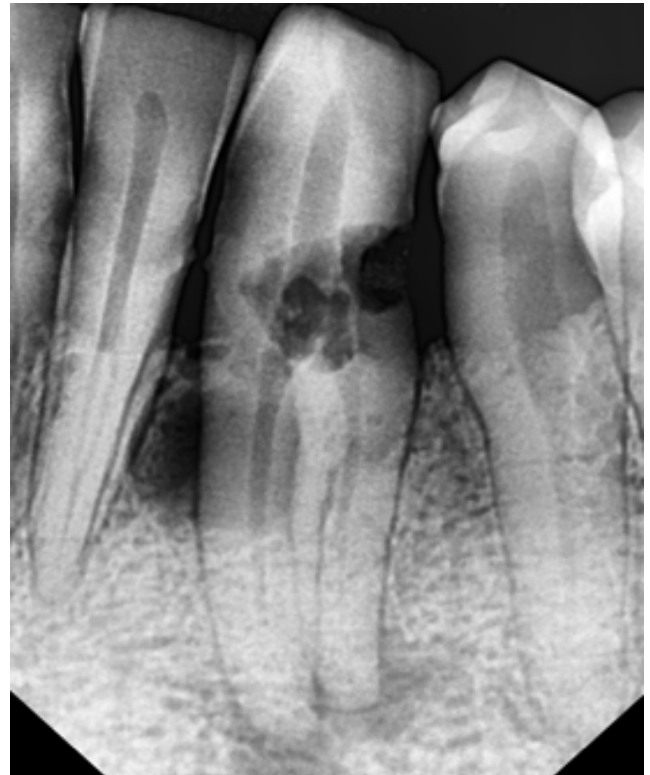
Diagnostic radiograph showing two separate roots with dental caries and pathology wrt #43.
